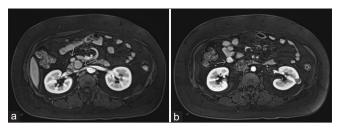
Magnetic resonance imaging of the abdomen and pelvis, (a) two nodules (1.6 cm and 1.2 cm) of low signal on T1WI at the pancreatic head; (b) a 1.3-cm lymph node near the pancreatic head with high signal on T1WI
